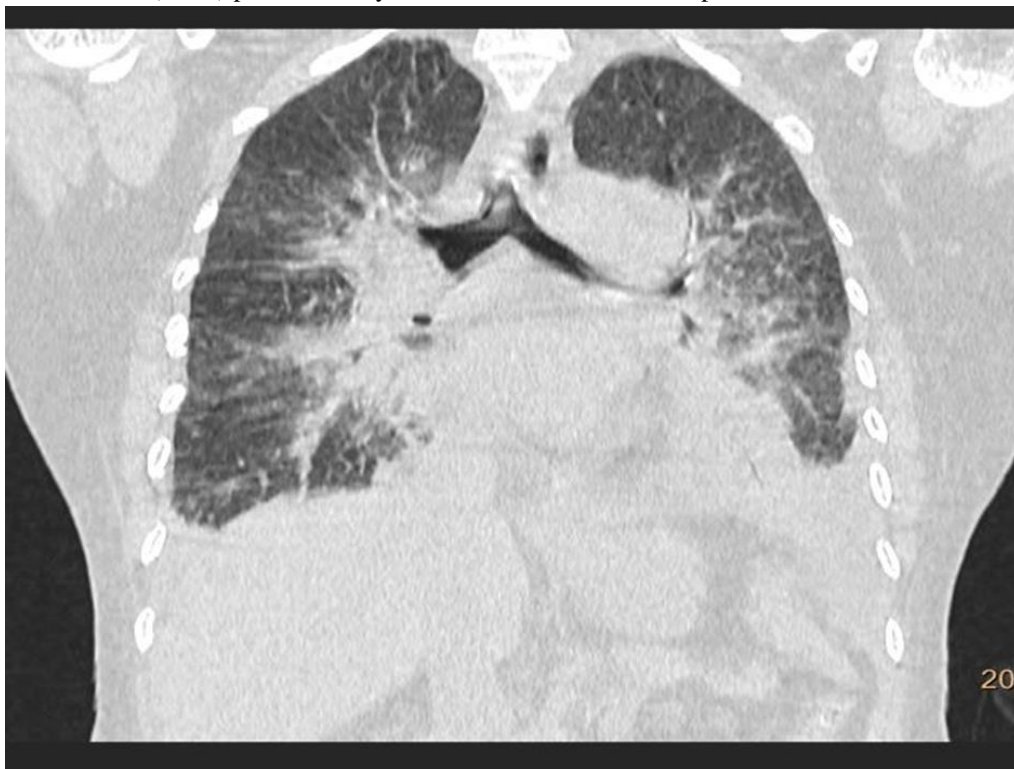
Coronal section of HRCT Thorax showing diffuse bilateral central peri-bronchovascular Ground glass opacities.
